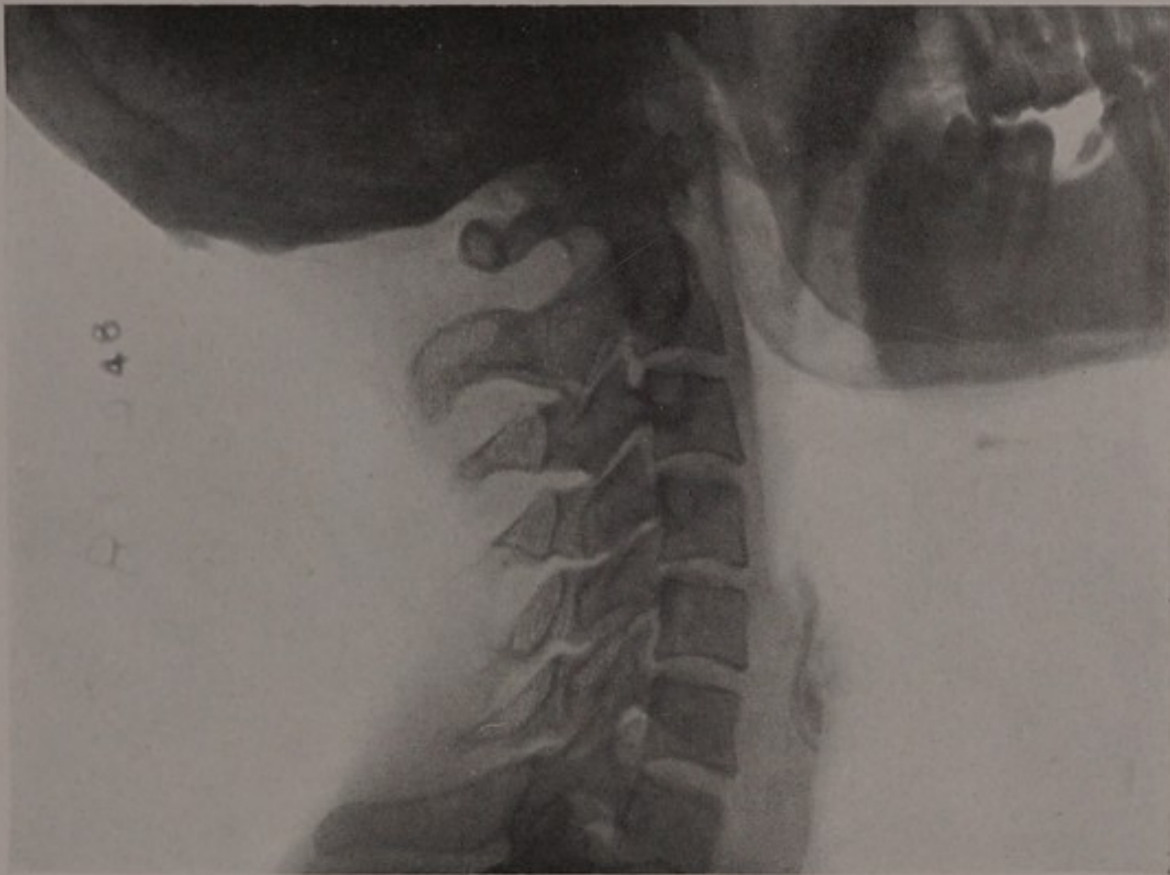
X-ray of the cervical vertebræ from the side.
